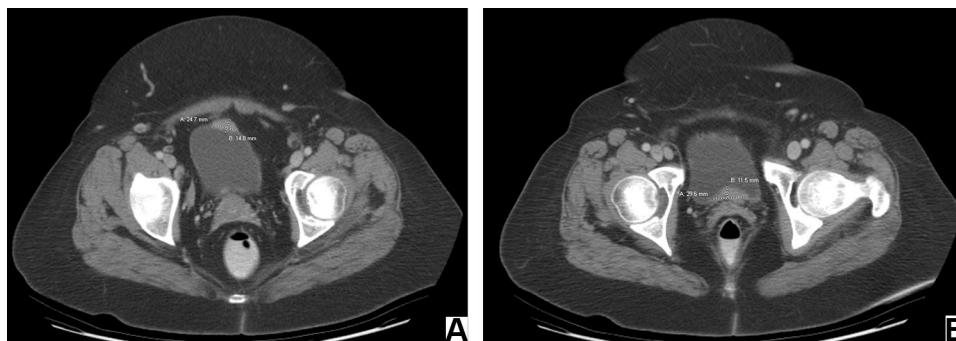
Axial CT images showing multiple abnormal nodular thickening on the anterior (A) and posterior (B) bladder walls.
